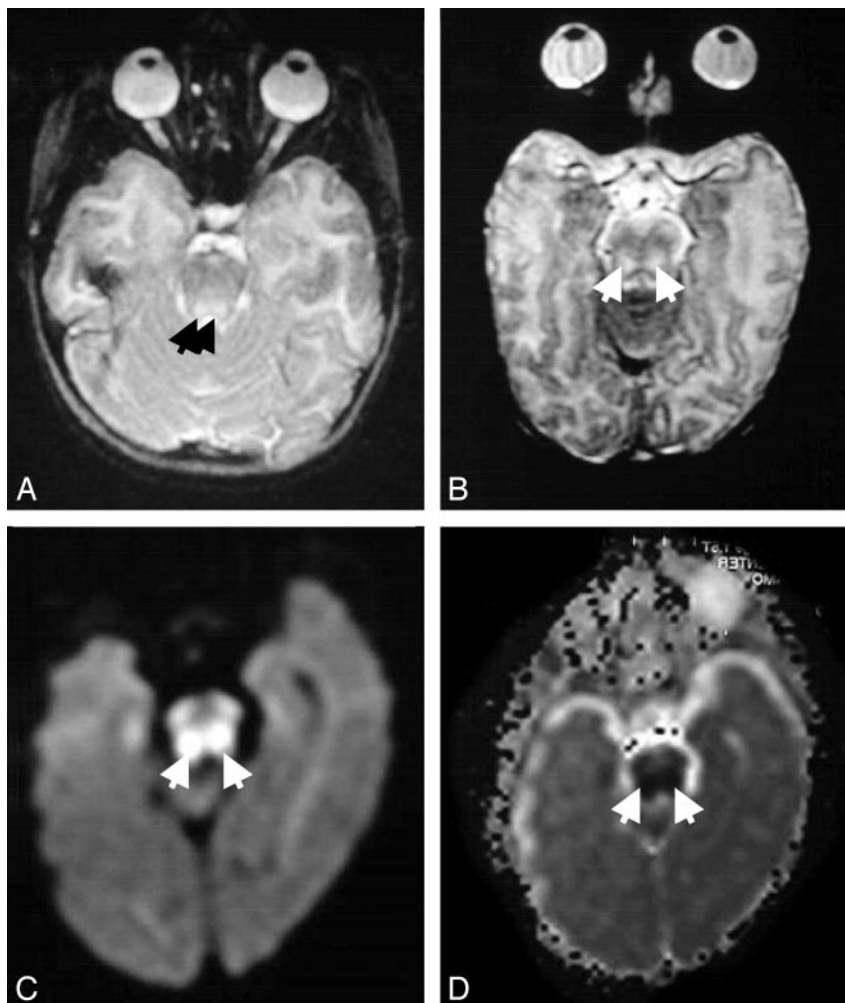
T2-weighted MR images show increased signal diffusely in white matter and focally within the dorsal brain stem (arrows) for patients 1 (A) and 2 (B). For patient 3, note that signal is increased in the $b = 1000$ image (C) and correspondingly decreased in the ADC map (D), indicative of restricted diffusion (arrows).
